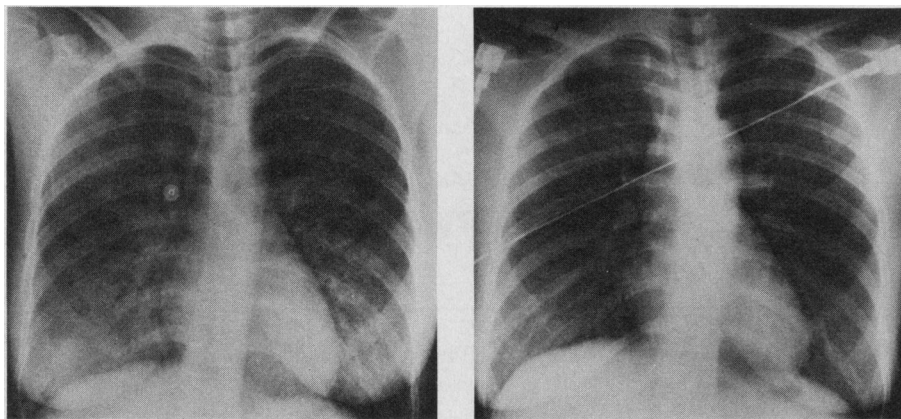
Left: Diffuse pulmonary edema without cardiomegaly on admission. Right: Clearing within 24 hours. Both radiographs taken during inspiration with patient erect.
